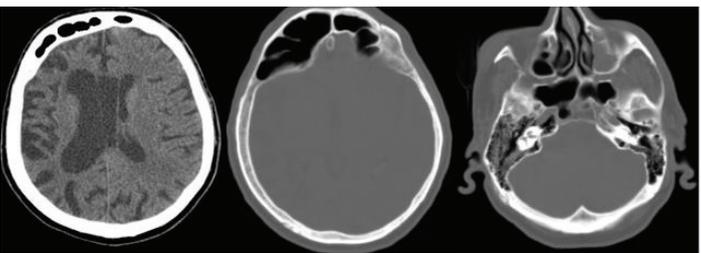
CT showed cerebral hemiatrophy, mastoid cell and sinus hyperpneumatization.
